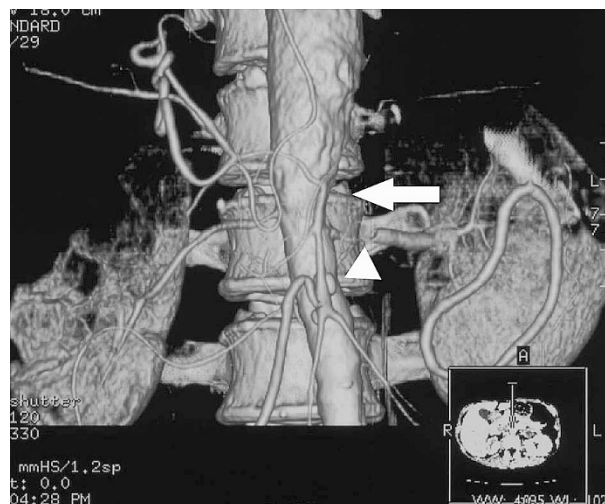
Post-contrast three-dimensional CT scan image of the aorta showing some irregularity of the wall (arrow), non-enhanced lesions involving the entire upper pole of both kidneys, and stenosis of the renal arteries (arrowhead), celiac artery and superior mesenteric artery.
